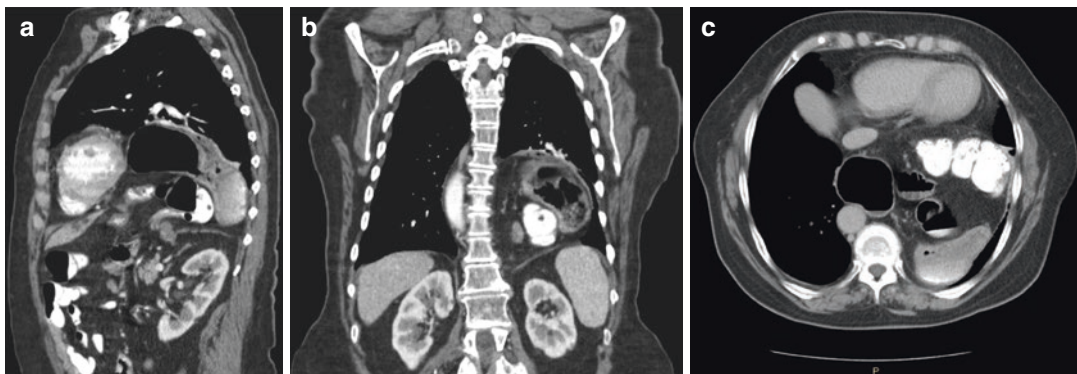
Computed tomography showing a Type IV paraesophageal hernia; (a) sagittal plane; (b) coronal plane; (c) axial plane
